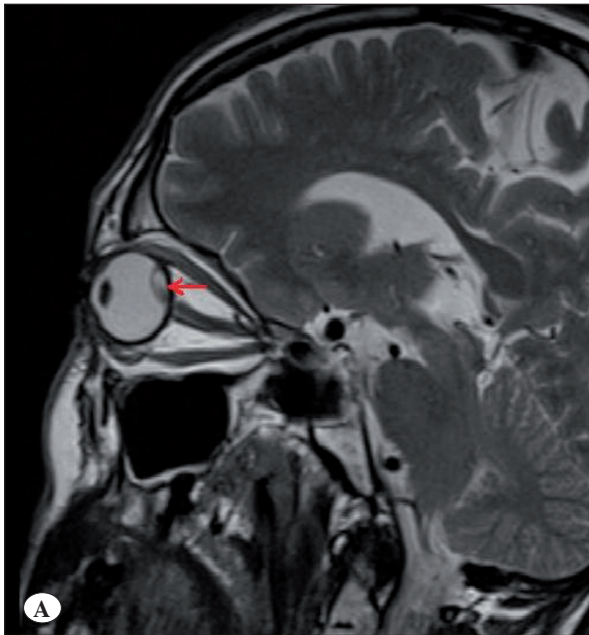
MRI examination of cranium and orbita, a lesion placed at the left bulbus oculi, at the superior margin of optic disc and lies in the vitreous humour within the choroid tissue.
